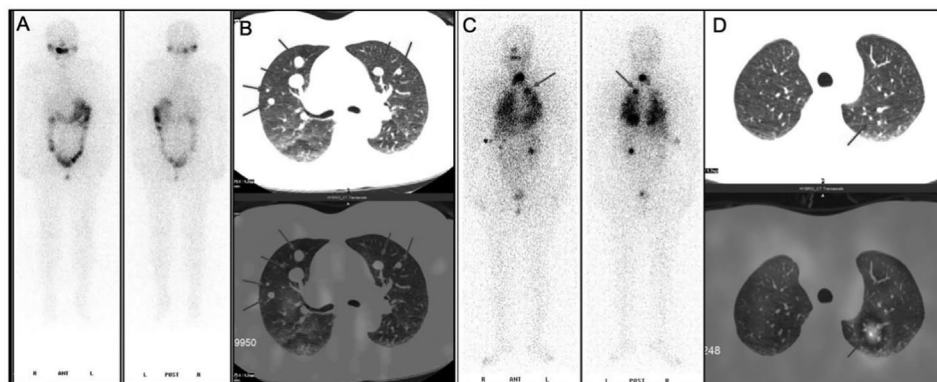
^{131}I whole-body scan (^{131}I -WBS) after radioiodine therapy. (A, B) ^{131}I -WBS and CT image of a patient without iodine uptake of lung metastases after ^{131}I remnant ablation successful. (C, D) ^{131}I -WBS and CT image of a patient with iodine uptake of lung metastases.
